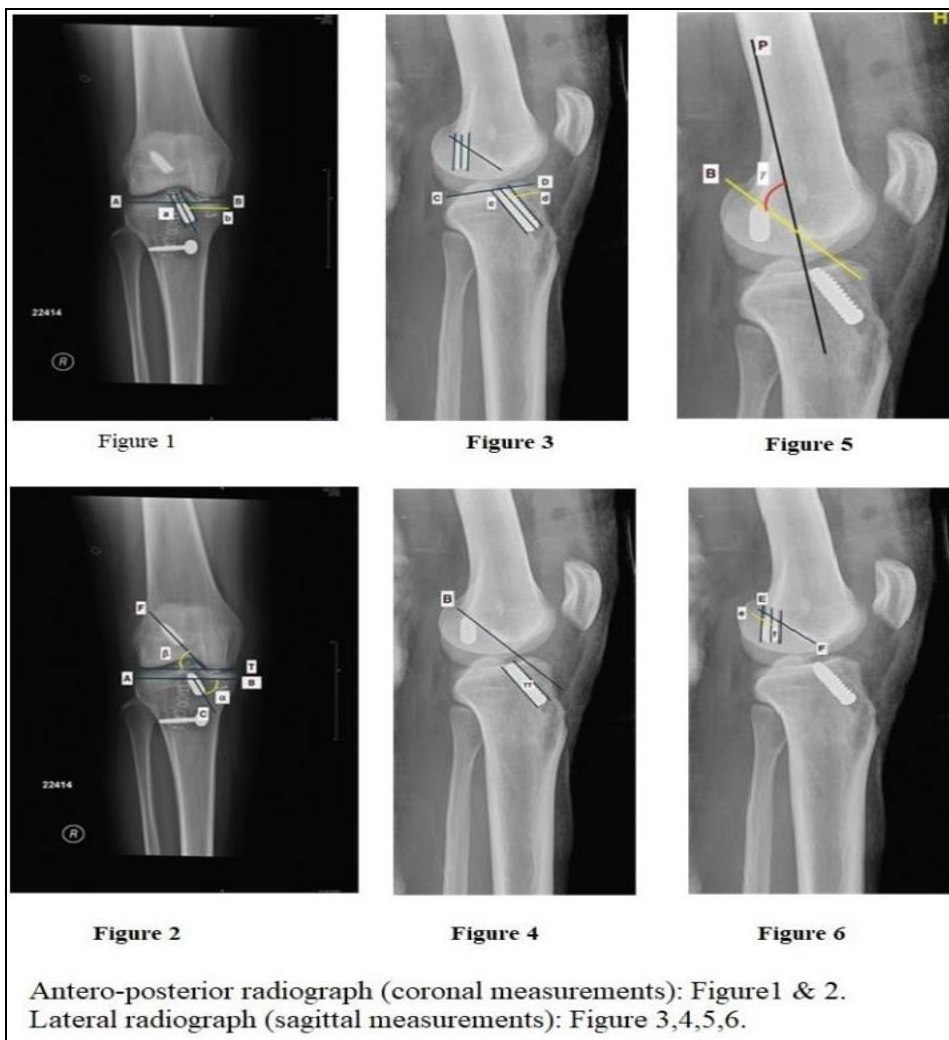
Antero-posterior radiograph (coronal measurements): Figure 1 & 2 Lateral radiograph (sagittal measurements): Figure 3, 4, 5, 6.
